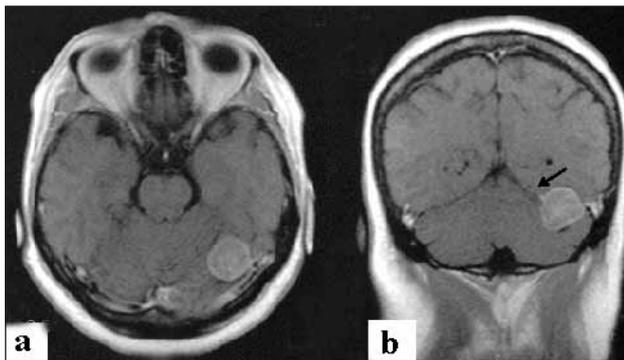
Cranial axial (A) and coronal (B) MRI examination showing a 22x24 mm extra axial, well-demarcated, mass lesion based on the left tentorium. The mass enhanced diffusely after intravenous Gadolinium injection and the dural tail sign was positive (black arrow).
